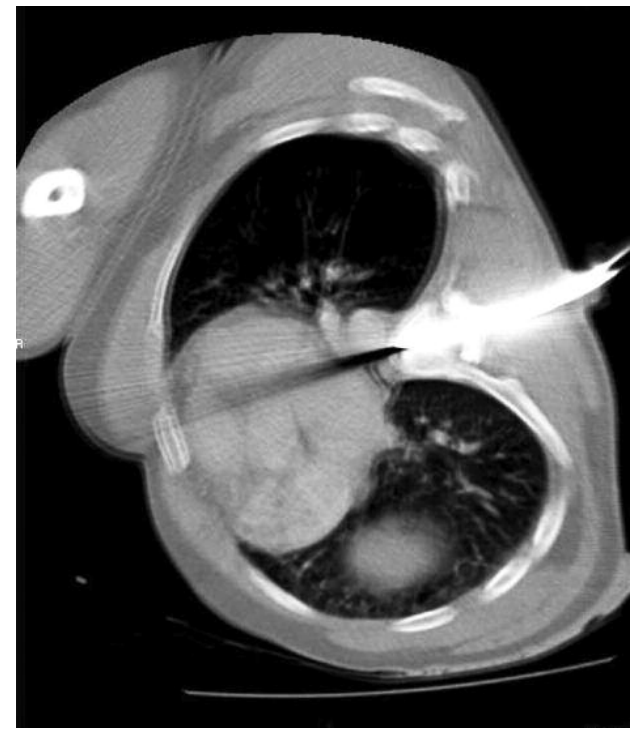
The shape of the knife entry in thoracic vertebral CT.
